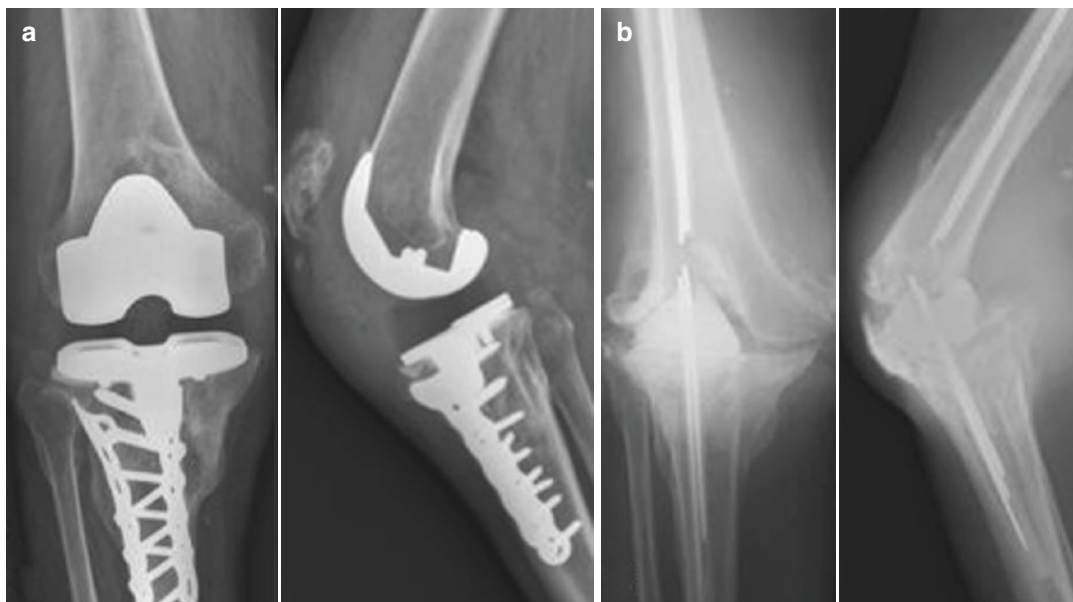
Case report: A 69-year-old man had chronic sepsis of his TKA with chronic rupture of the patellar tendon. (a) Radiograph before revision. (b) Radiograph after the first stage revision showing a broken static cement spacer
